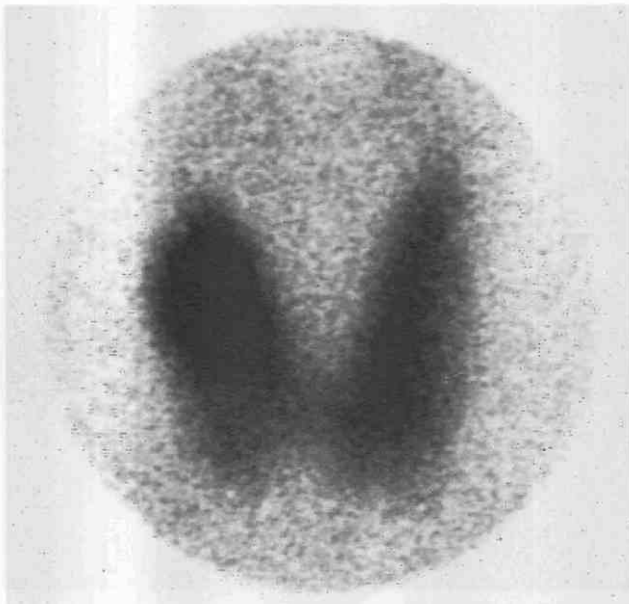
With technetium 99m-pertechnetate scintigraphy, an anterior view identifies a solitary hyperfunctioning nodule in the upper pole of the right thyroid lobe. Extranodular thyroid activity is not suppressed, consistent with a diagnosis of euthyroidism.
